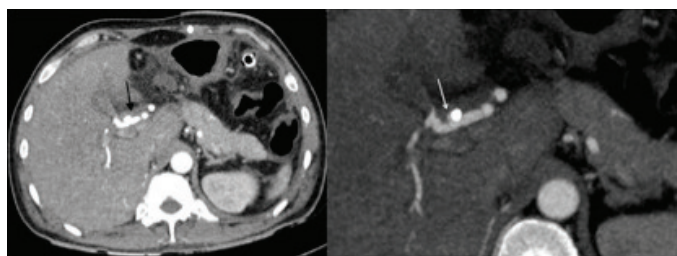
CT angiography arterial phase imaging (a): is showing a biliary catheter in relation to the right hepatic artery. Zoomed up image with a wide windowing (b): is showing a fine streak of contrast around the catheter, which was masked by the blooming around hyper-dense catheter on routine windowing.
